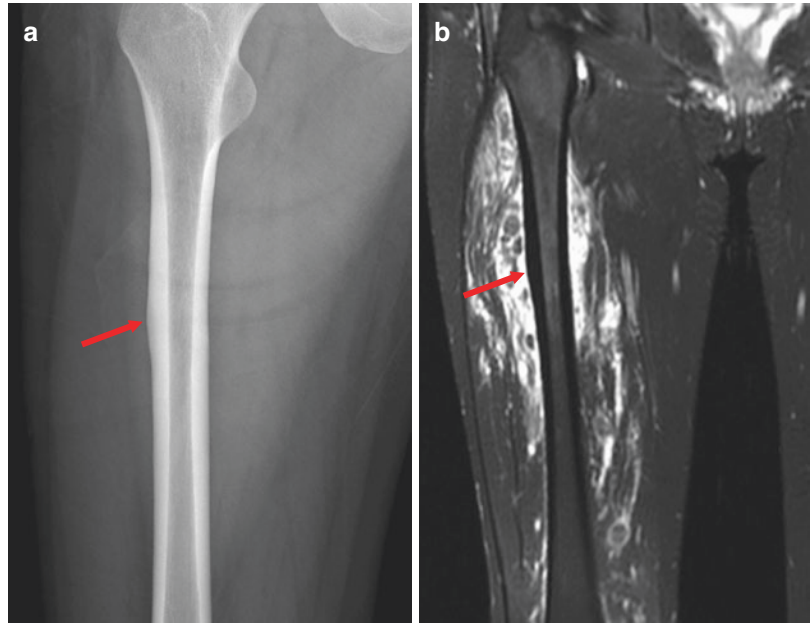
Synovial sarcoma. AP oblique radiograph (a) shows a nonspecific calcification (*arrow*) on the lateral side of the left mid lower leg. Coronal postcontrast FS
